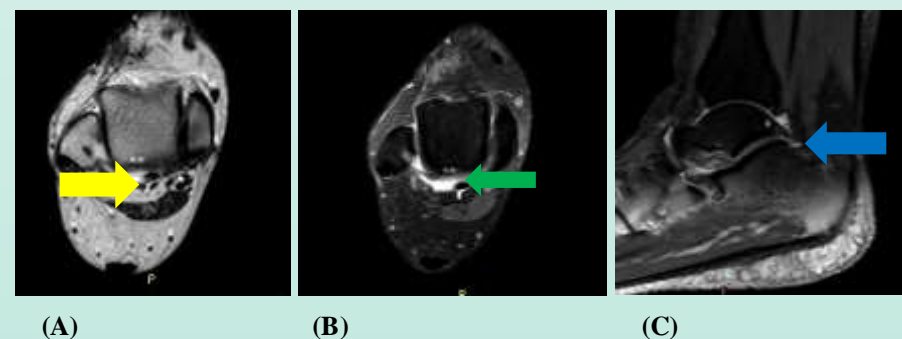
33 Female patients presented with posterior right ankle pain MRI examination revealed; (A) axial T1 WI sequence showing mild flexor hallucis longus tenosynovitis (yellow arrow), (B) axial PDW FS sequence showing posterior ankle synovitis (green arrow) and (C) sagittal PDW FS sequence showing Os trigonum (blue arrow)
